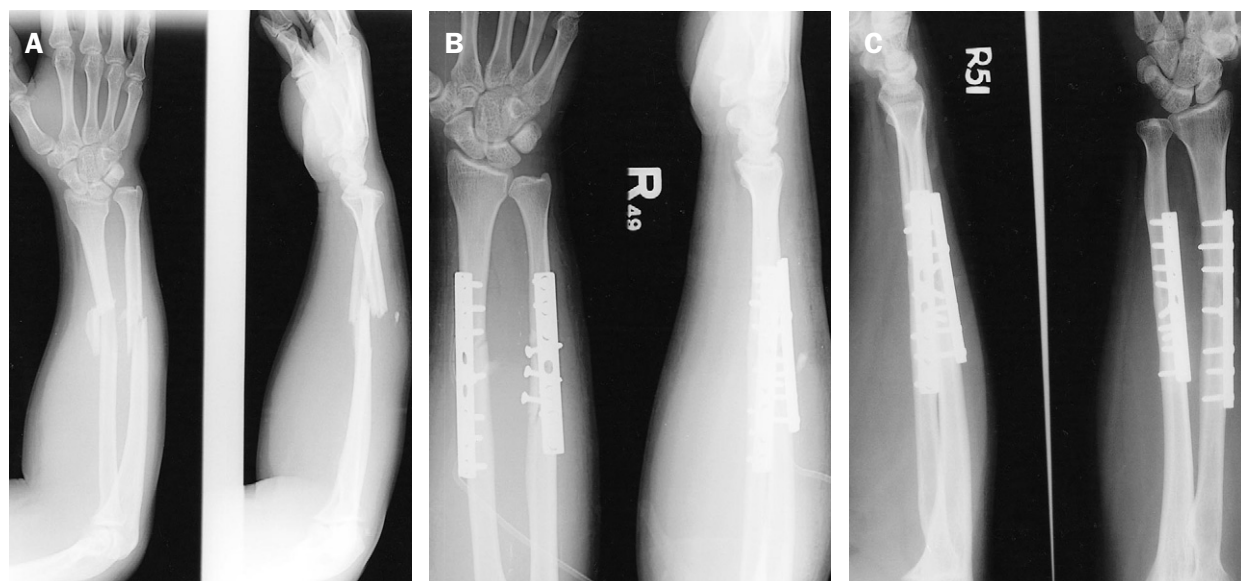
(A) Preoperative plain radiographs of the right forearm of a 25-year-old male with open type I fractures of the right radius and ulna, M/3, comminuted. (B) Immediate postoperative plain radiographs of the right forearm of the same patient showing 2 dynamic compression plates. (C) Plain radiographs 20 months postoperatively of the right forearm of the same patient shows solid union of the radius and ulnar fractures.
